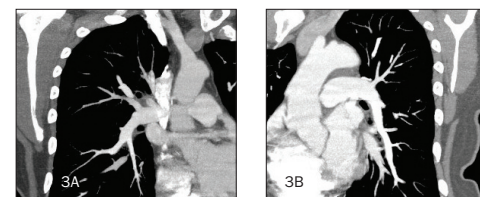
Follow-up CT angiography at 6 months demonstrated normal (A) right and (B) left PA with no evidence of thrombus.
